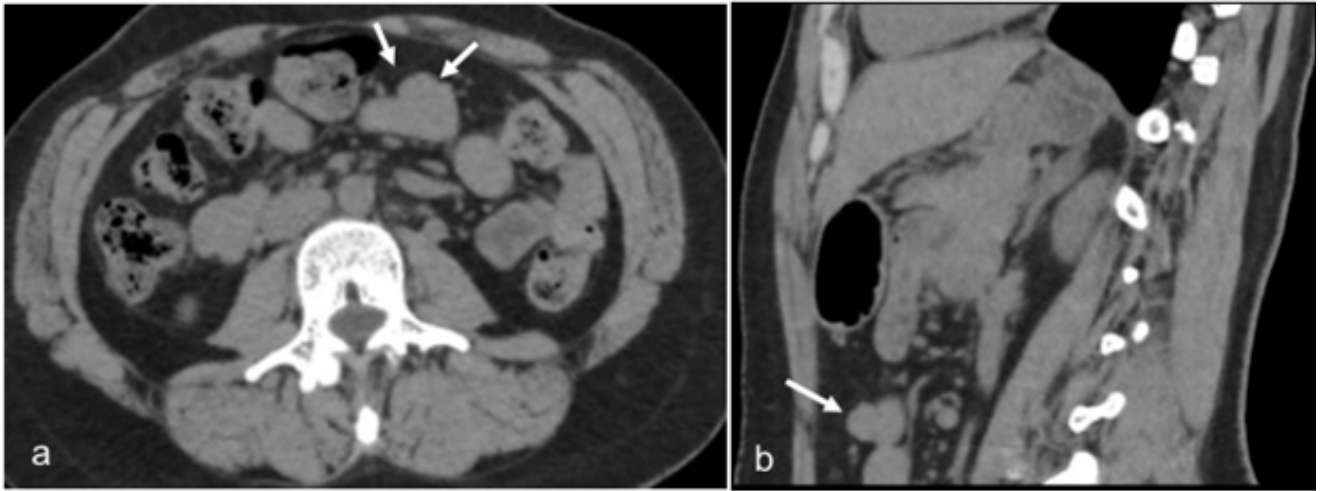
a, b: Plain CT in the axial and sagittal section shows a lobulated isodense lesion producing a contour change in the jejunum (white arrow).
